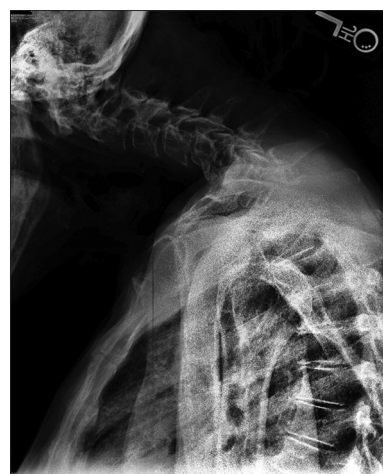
The baseline lateral cervical radiograph of a 67 year-old female who underwent cervical deformity corrective surgery. She underwent a reoperation due to neurologic complications. According to the proposed PR modifier, the patient presented with severe TS-CL (62.3°), CL (-32.3°), C2-T3 (-49.9°), and C2 slope (67.1°) modifiers, while was categorized with moderate baseline Patient-reported modifier deformity for McGregor's Slope (10.6°) and presented as Patient-reported low frailty (0.13) at baseline
